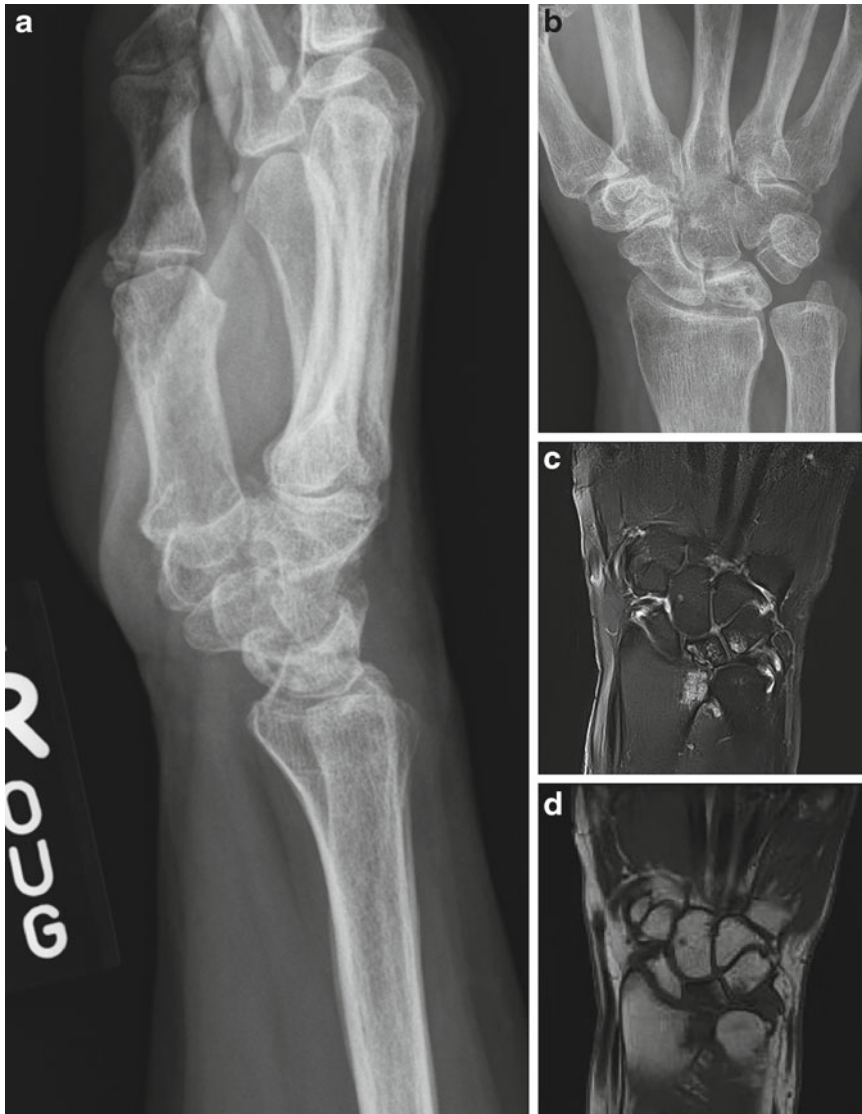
(a) Lateral radiograph of a 68-year-old female with Kienböck's disease, showing sclerosis with cystic changes of the lunate. (b) This PA wrist radiograph of the same patient shows evidence of pancarpal arthritis, with lunate sclerosis and collapse consistent with Kienböck's disease. There are cystic changes at the distal radius as well. (c) T2-weighted MRI of the same patient showing
